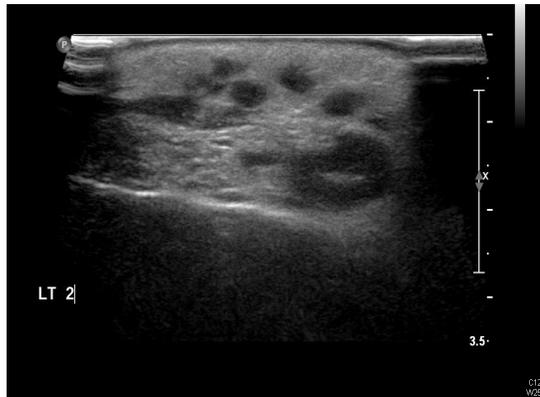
Ultrasonography Image Showing a Multiple Superficial, Left Facial Abscesses
